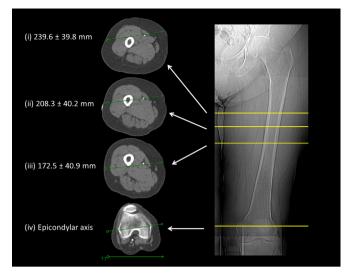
Right panel:* scanogram of the left thigh with transverse cutlines corresponding to axial sections. *Left panel:* axial images of the left thigh showing key points with distances from the AT listed in millimetres. The region from (i) to (iii) corresponds to the danger zone, the region distal to (iii) corresponds to the safe zone.(i). The superior crossing point of the SFA in relation to the shaft of the femur as it traverses from anterior to posterior in the sagittal plane.(ii). The middle crossing point of the SFA on the shaft of the femur.(iii). The inferior crossing point of the SFA in relation to the shaft of the femur as it passes posterior to the femur in the sagittal plane.(iv). The epidcondylar axis which is demonstrated to be 7.7 degrees from the horizontal axis of the CT gantry in this patient.
